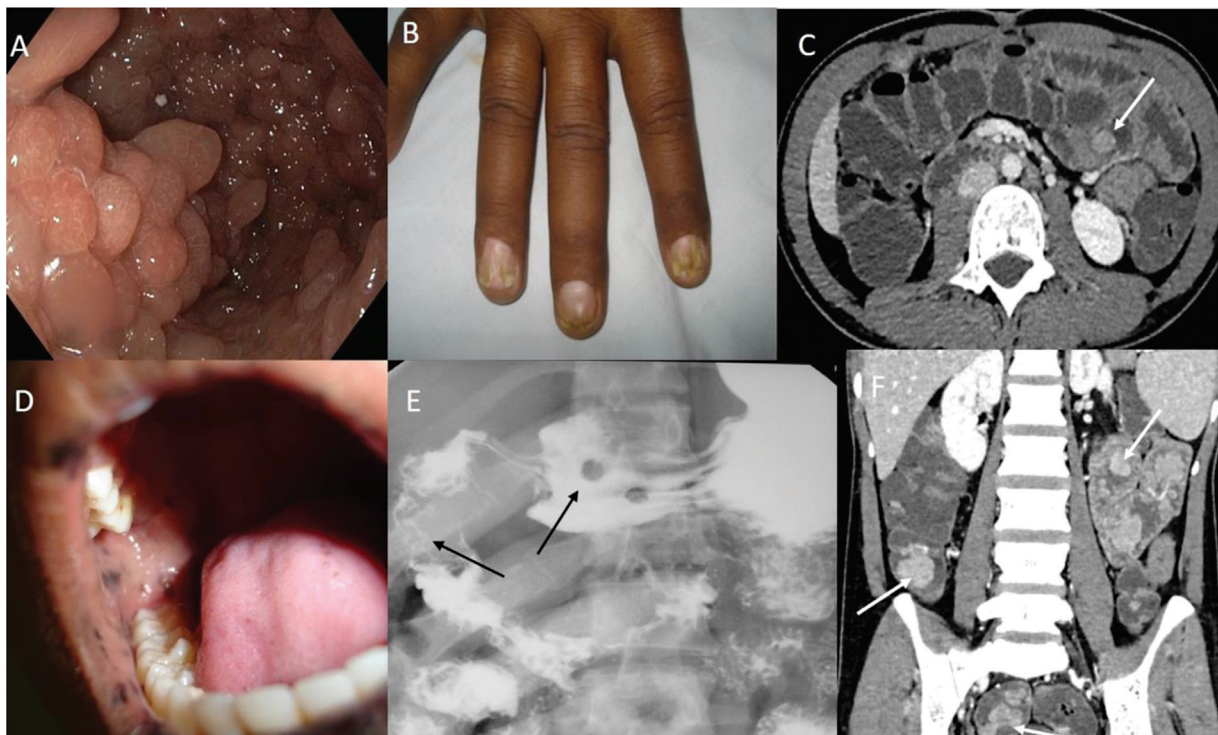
Polyps: (A) Endoscopic image showing multiple polyps and (B) involvement of fingernails in Cronkhite-Canada syndrome; (C) Axial computed tomography (CT) enterography showing well-defined round homogeneously enhancing polyp in the jejunal lumen (arrow); (D) Circumoral muco-cutaneous pigmentation; (E) Barium meal follow through showing round filling defects (consistent with polyps) in the antrum of stomach (arrows) and (F) Coronal CT enterography section showing multiple enhancing polyps within the small and large bowel (arrows).
